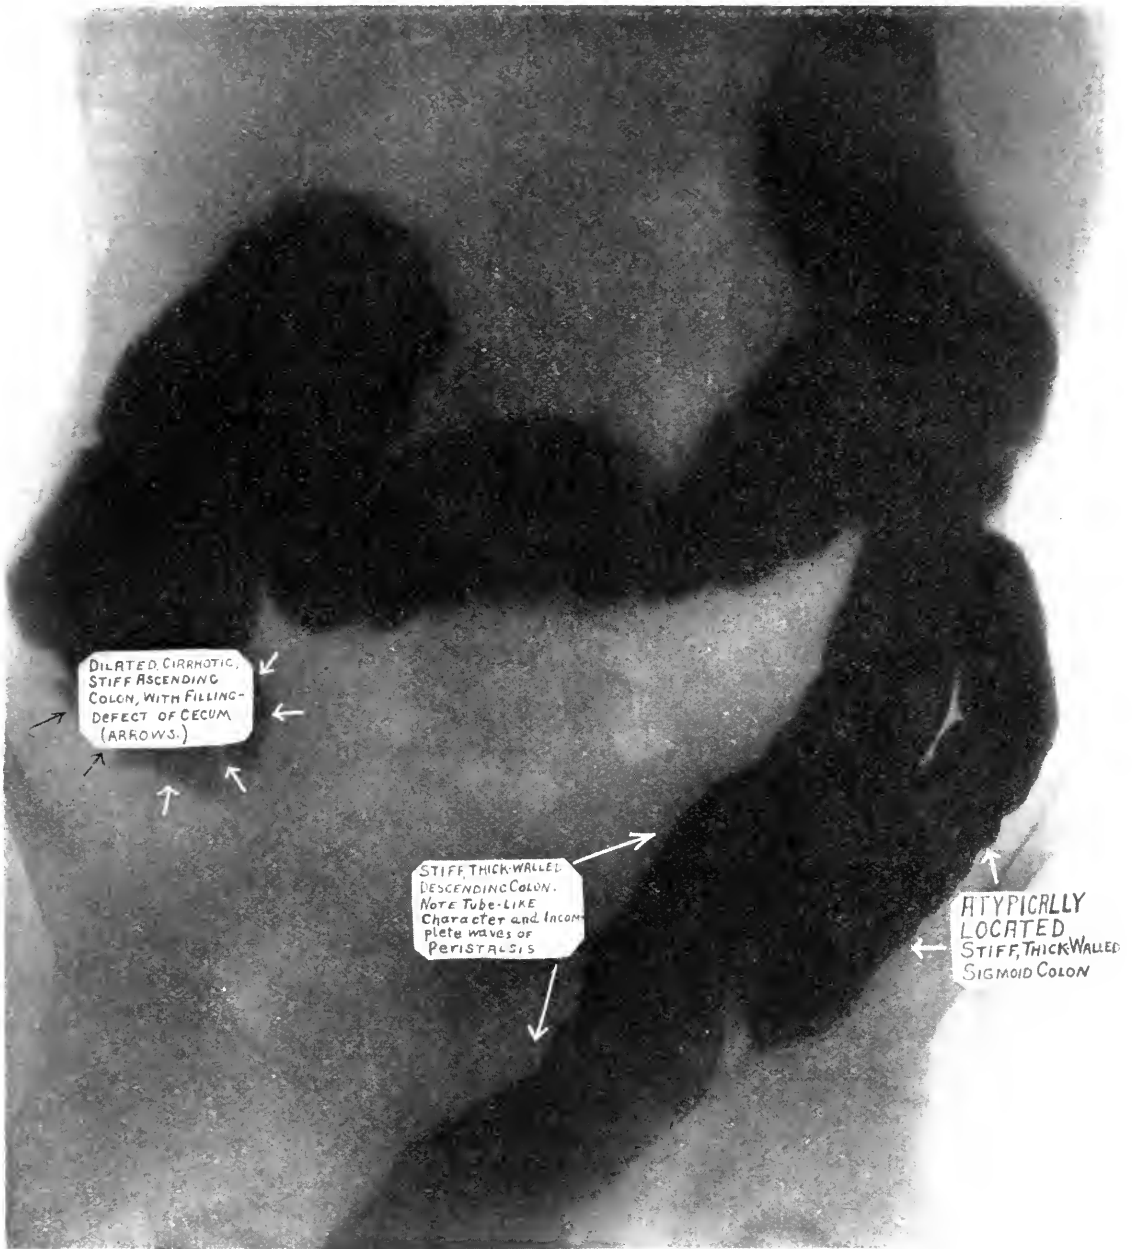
Case 3. Roentgenogram of the colon, with sites of luetic lesions indicated. (Joseph Johnson, roentgenographer.)
